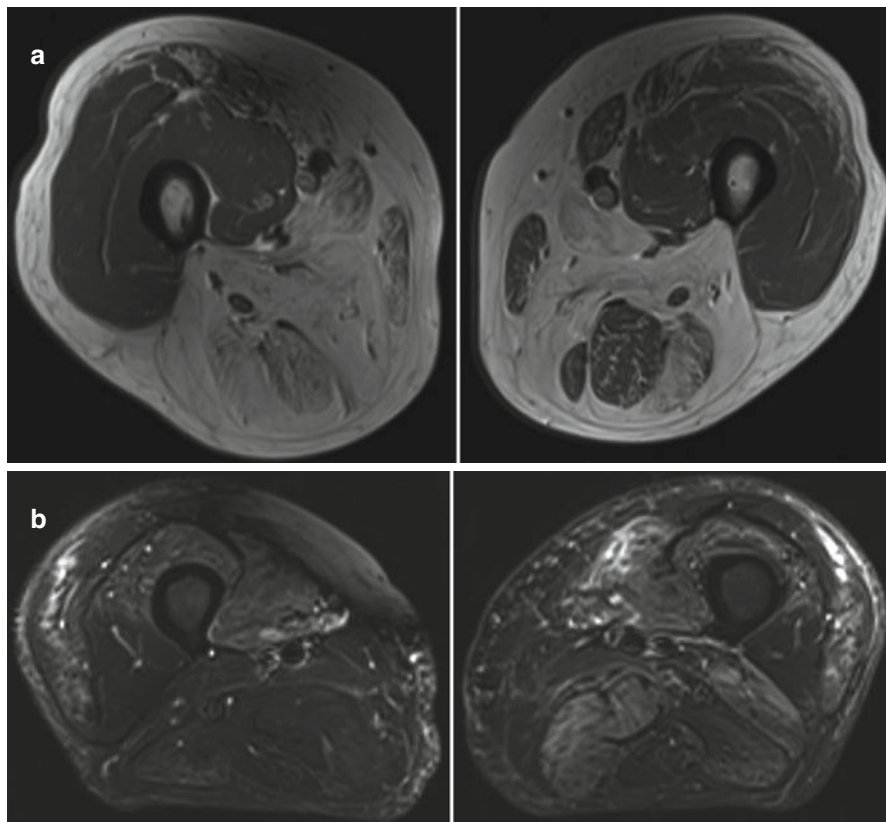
MRI thighs: (a) T1 image: this shows almost complete fatty replacement of the muscles of the posterior and medial compartment of thighs on the *right* and to a lesser extent on the *left*. The vastus lateralis muscle bilaterally as well as the inferior portion of the rectus femoris muscle on the *left* are also severely affected. (b) STIR image: there is a high signal indicating water deposition in the medial vastus, rectus femoris and vastus lateralis muscles bilaterally as well as the *left* adductor and semimembranosus muscles
